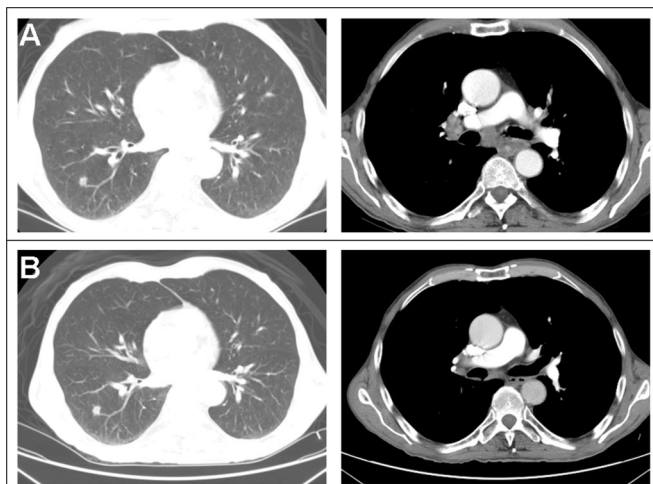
A, Representative images from the chest computed tomography (CT) performed at the onset of symptoms showing a 9-mm right lower lobe pulmonary nodule and lymphadenopathy in the subcarinal lymph nodes with a maximal diameter of 2 cm. B, Chest CT obtained approximately 6 months after the initial CT, demonstrating stability in the right lower lobe nodule and regression of the subcarinal adenopathy.
